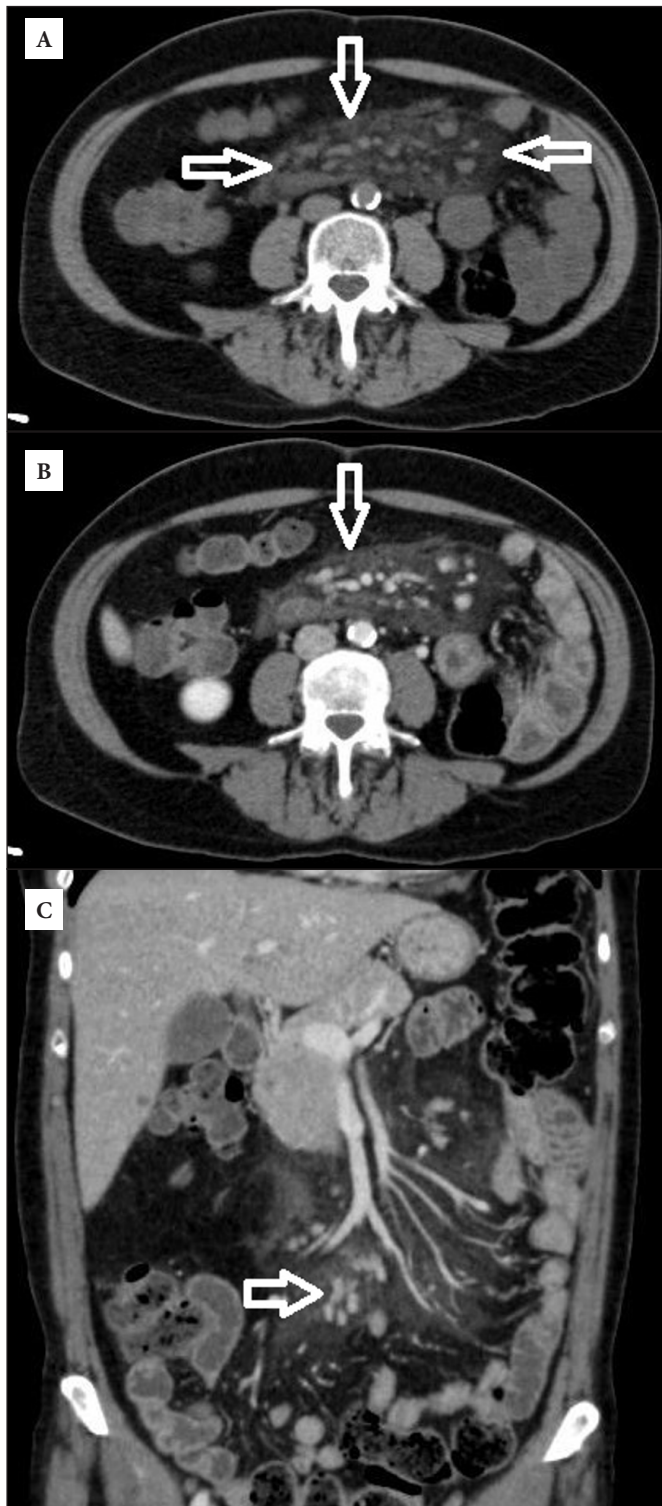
57-year-old male patient complaining of abdominal pain. Contrast and pre-contrast CT images show a fat mass lesion in the mesentery (A), increased mesenteric fat tissue density (B) and mesenteric lymph nodes in the perivascular region (C).
